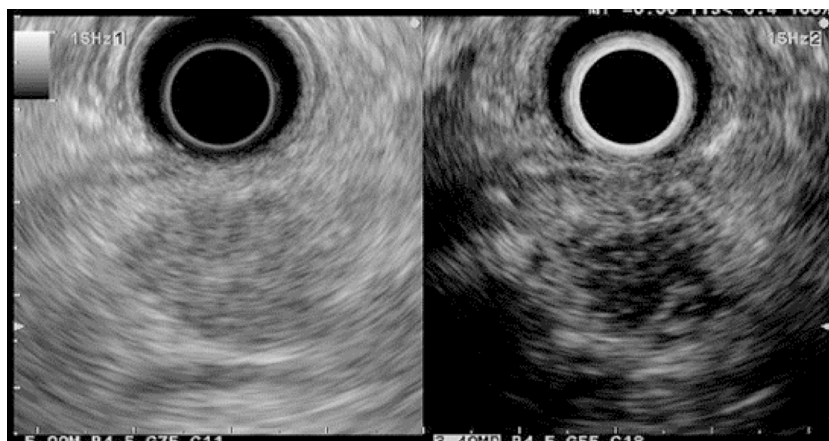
Contrast-enhanced harmonic in endoscopic ultrasound: Hypoechoic suspect nodule.
